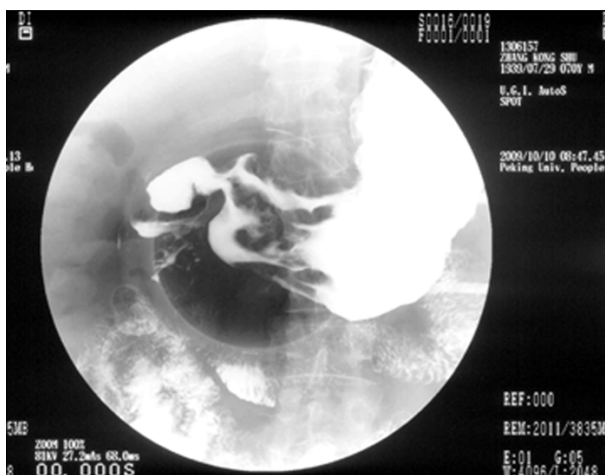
Posteroanterior Radiograph from an upper Gastrointestinal Series in a Patient with Gastric Lymphoma show some of the Mucosal Folds of Gastric Antrum are Evidently Coarse, and irregular, manifest as a linear filling defect, while the local stomach wall is still and cannot expand, and peristalsis disappears.
